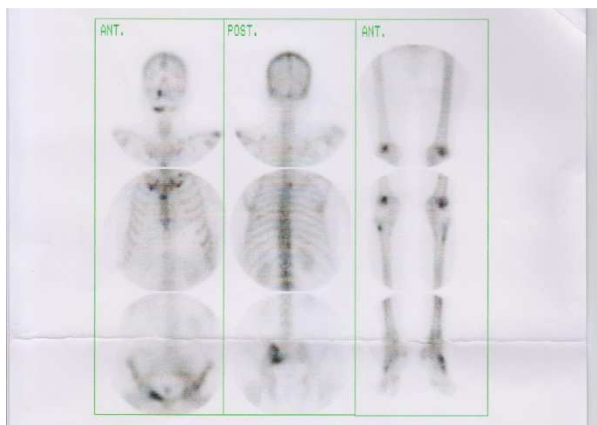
Whole body bone scintigraphy showed increased activity in thoracolumbar spine, left side of the sacrum and right superior ramus
